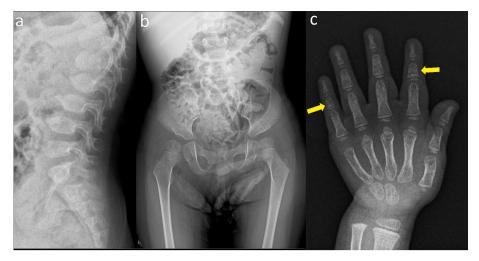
Plain radiographs of the lumbar spine (a), pelvis (b), and left hand (c) at 4 years of age: Progression of spondylar dysplasia associated with platyspondyly (flattening of the vertebral bodies) is noted. Anterior central bone projections are more prominent at L2, L3, and L4. The proximal femoral epiphyses appear large and round. Flared ilia and acetabular dysplasia are seen again. Mild brachymesophalangy (shortening of the middle phalanges) is seen in the index and little fingers (arrows).
